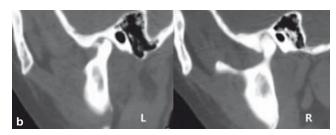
Coronal image (a) and sagittal image (b) of CT scan revealing bilateral joint space narrowing, irregular surface of the condyle, sclerosing and bony adhesion of the condyle with articular eminence and fossa.
